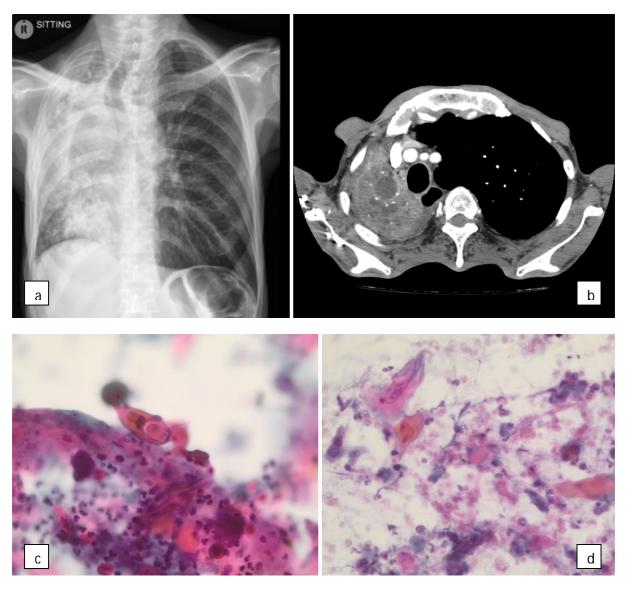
Complete collapse of the entire right lung with a central mass and local invasion on chest X-ray (a) and CT (b). Sputum – malignant. Keratinised pearls and cells with dense cytoplasm and hyperchromatic nuclei (c). TBNA - Squamous cell carcinoma with necrotic background (d).
